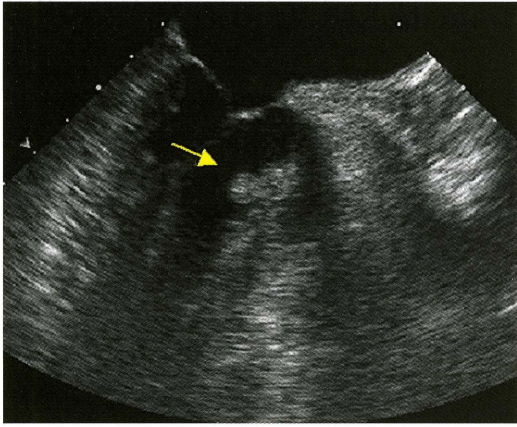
Transesophageal echocardiogram showing the tumor in the left ventricle.
